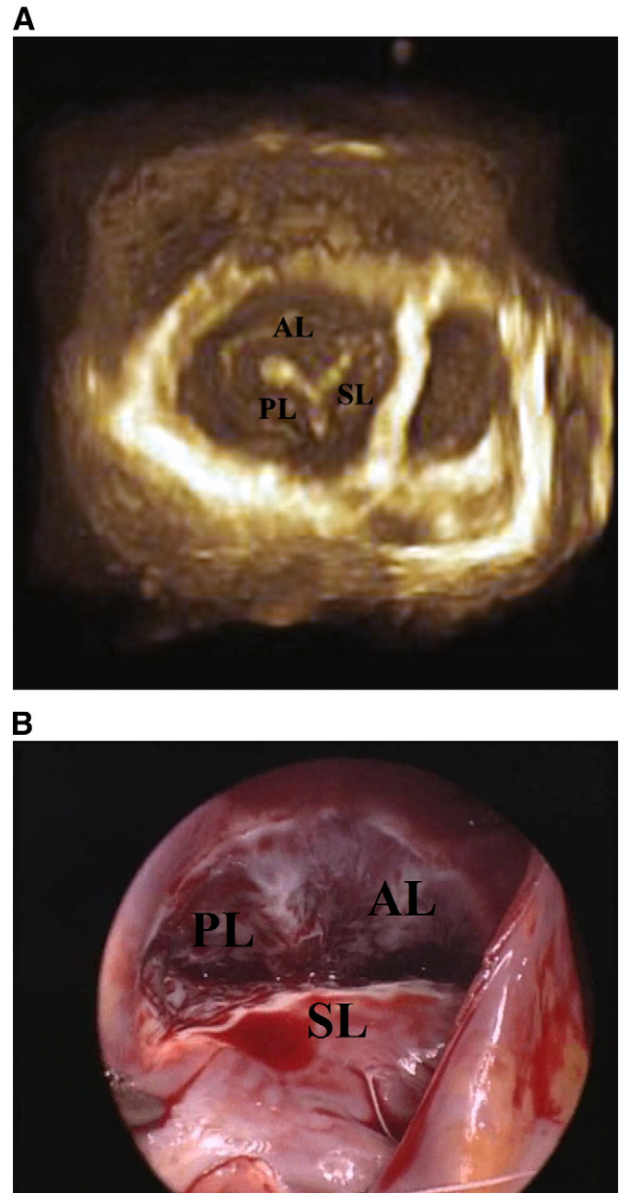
Three-dimensional transthoracic echocardiography (A) and intraoperative echocardiographic view (B) of the tricuspid valve. SL = septal leaflet, AL = anterior leaflet, and PL = posterior leaflet.
